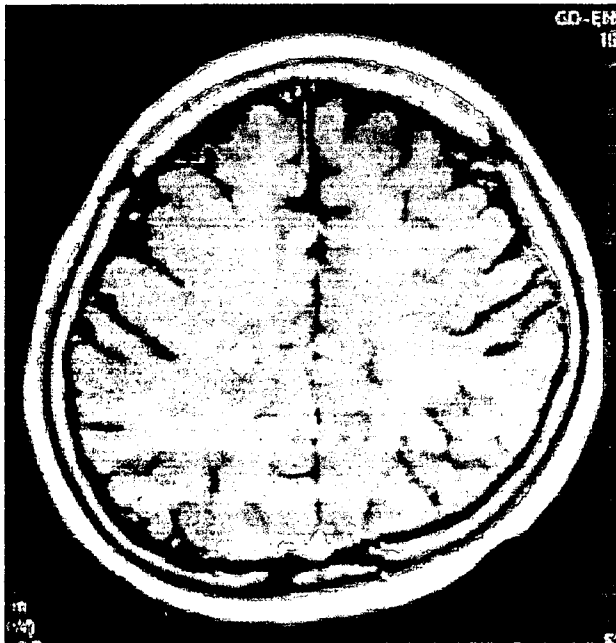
The metastatic lesions exhibited high signal intensity in the right temporal lobe by T1 weighted MRI.
